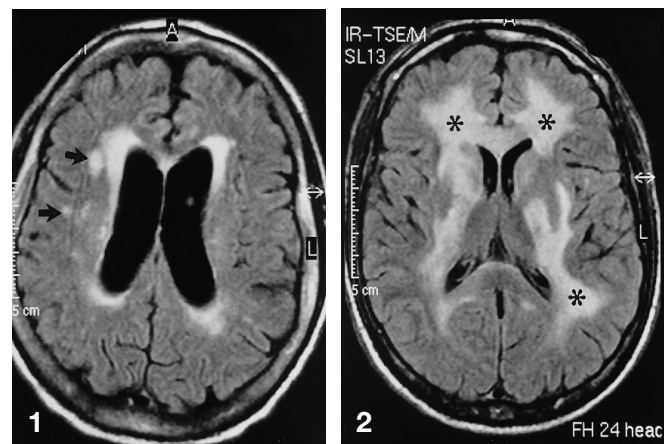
Human immunodeficiency virus (HIV) encephalitis (focal white matter lesions). A 30-year-old HIV-seropositive man presented with dementia. Fluid attenuated inversion recovery (FLAIR TR/TE/TI 7000/150/2100) MR image showed multiple, small, periventricular white matter lesions. Note sulcal and ventricular enlargement due to cerebral atrophy
